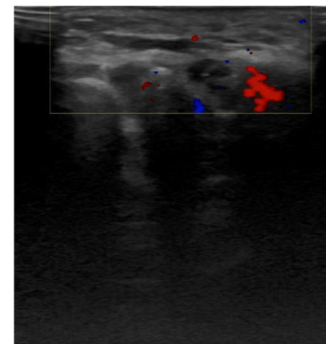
Ultrasound image. Small thickenings of subcutaneous cellular tissue, partially defined, without deep involvement. No pathological vascular structures or well-demarcated vascular enhancement foci.
